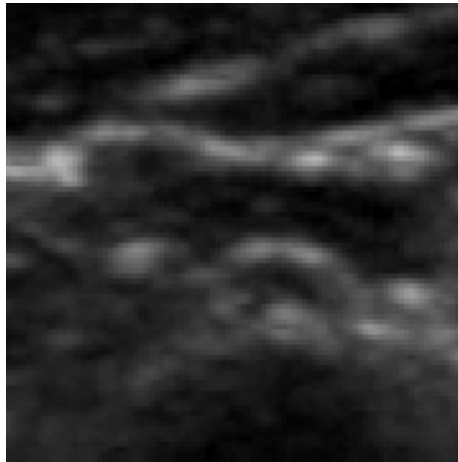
A sample ultrasound label patch where the IJV is entirely inside the patch.
